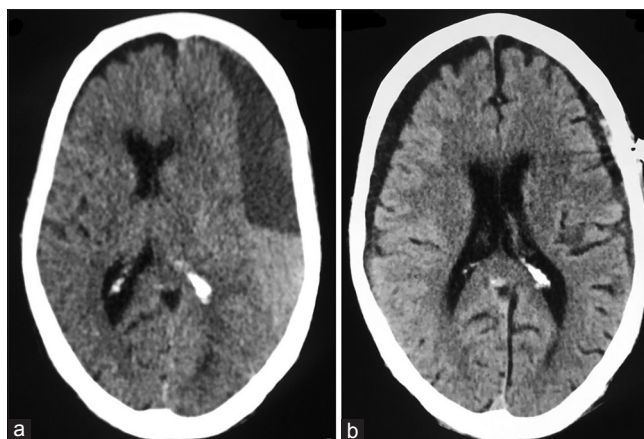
(a) Computed tomography scan showing left frontotemporoparietal chronic subdural hematoma with hyperdense gravity-dependent fluid level. (b) Computed tomography scan showing resolved left-sided chronic subdural hematoma following twist-drill craniostomy
